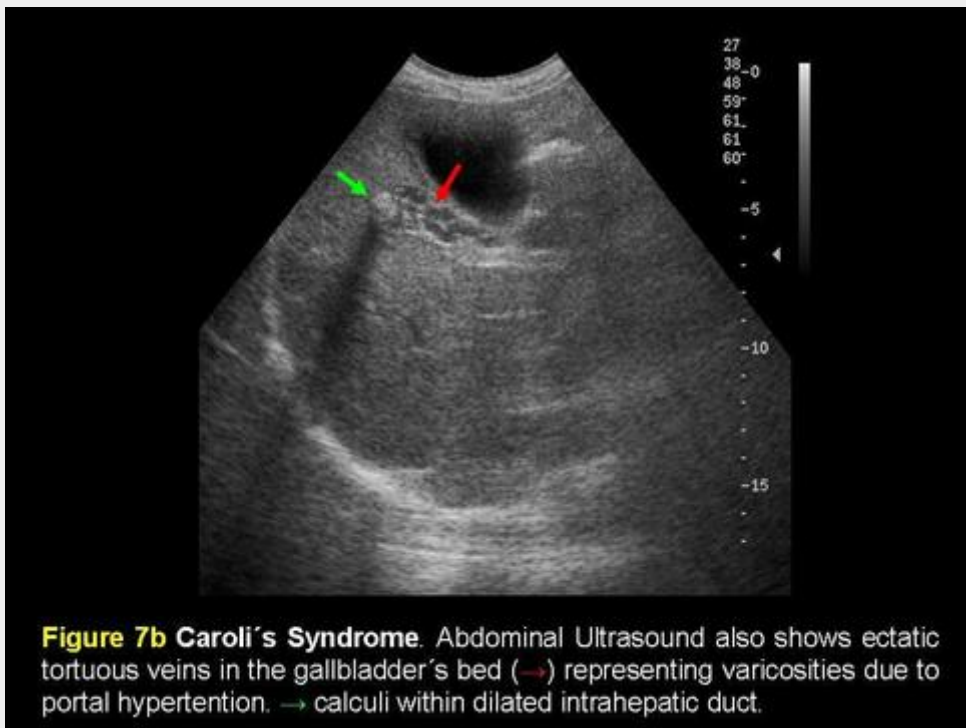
Caroli's Syndrome. Abdominal Ultrasound also shows ectatic tortuous veins in the gallbladder's bed (→) representing varicosities due to portal hypertension. → calculi within dilated intrahepatic duct.
